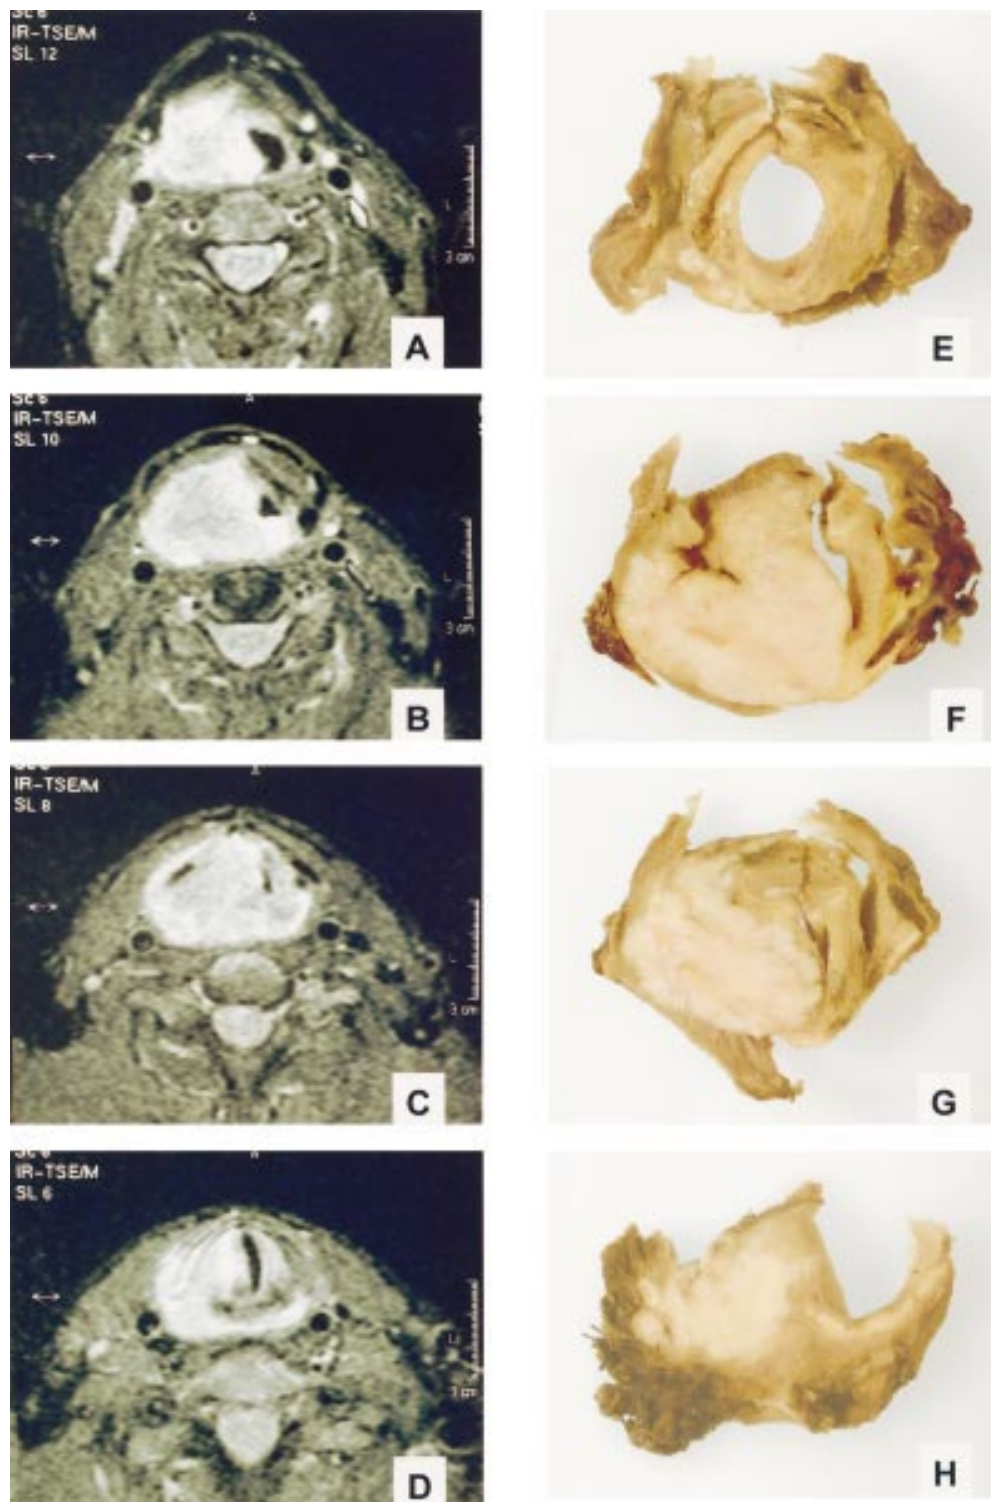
(A)–(D) Horizontal magnetic resonance images of the carcinoma seen in fig 1, showing invasion of the tumour along the right side of the larynx. The corresponding macroscopic slices of the larynx are shown in (E)–(H).
